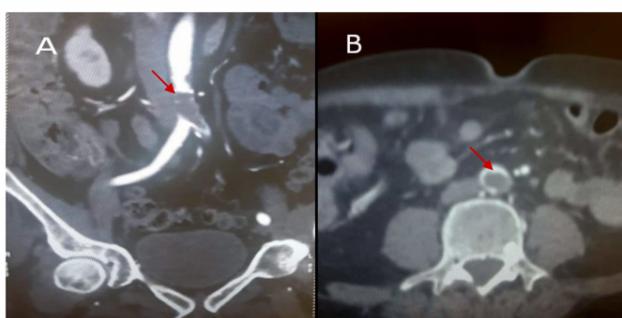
Computed tomography angiography image of floating mass obstructing practically the distal abdominal aorta and the origin of the left common iliac in an axial view (A) and sagittal view (B).
